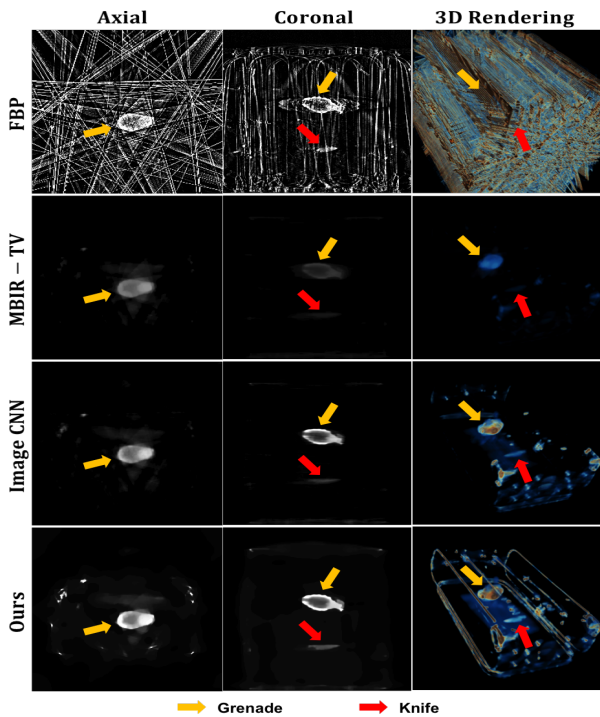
Reconstruction results by various methods from 9-views CT-EDS.
